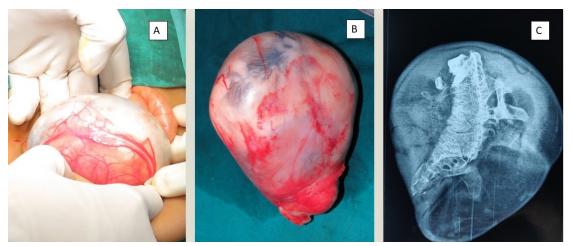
Case 1- A. Intraoperative well encapsulated mass, B. Excised mass – Showing hair at one end. C. Plain Radiograph showing the vertebral axis.
